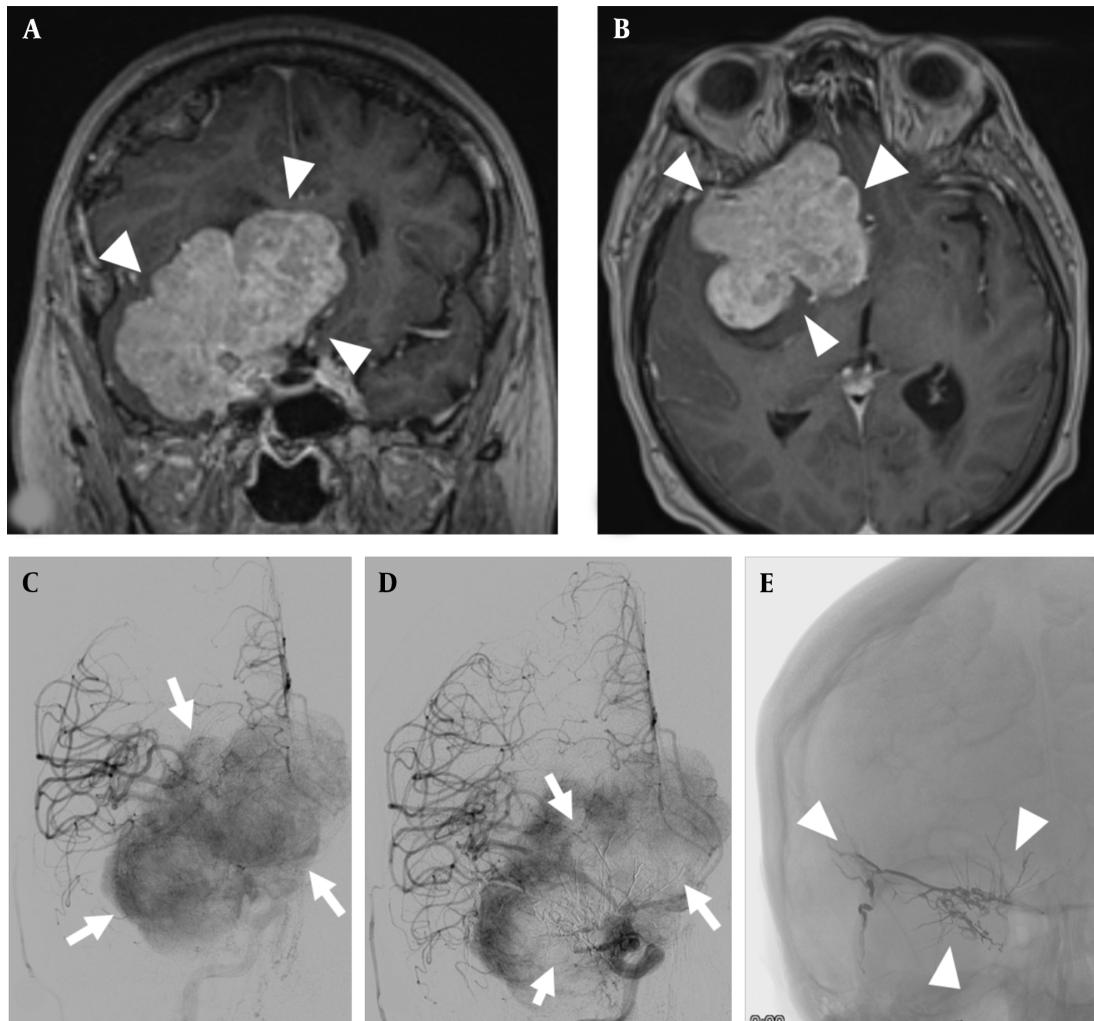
A and B, giant meningioma of the right greater sphenoid wing (arrowheads), coronal and transverse contrast-enhanced T1-weighted images; C, DSA with injection into the right common carotid artery showing a significant tumor blush in the late arterial phase (arrows); D, DSA with injection again into the right common carotid artery after embolization with a significant reduction in tumor blush in the center of the meningioma (arrows); E, radiograph without contrast injection showing the liquid embolic agent in the center of the tumor (arrowheads).
